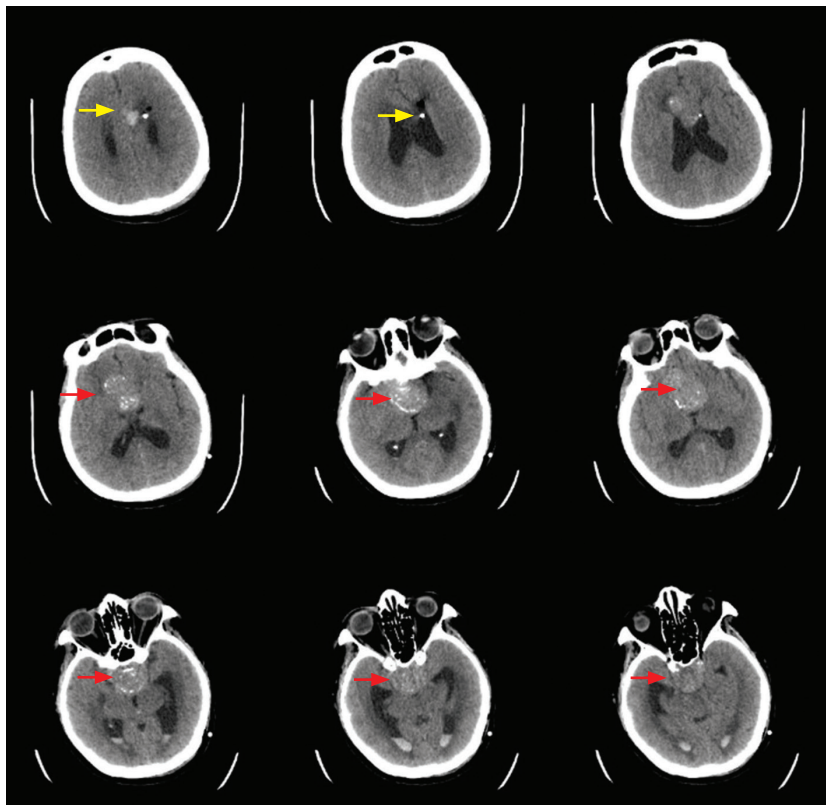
Post-operative transverse CT scan showing a 3.6 x 4.1 x 5.0 cm sellar-suprasellar mass, most likely a craniopharyngioma marked by red arrows. Ventriculoperitoneal shunt seen at the left frontal horn marked by the yellow arrows. Improved findings via a decrease in the dilation of the lateral horns can be noted.
